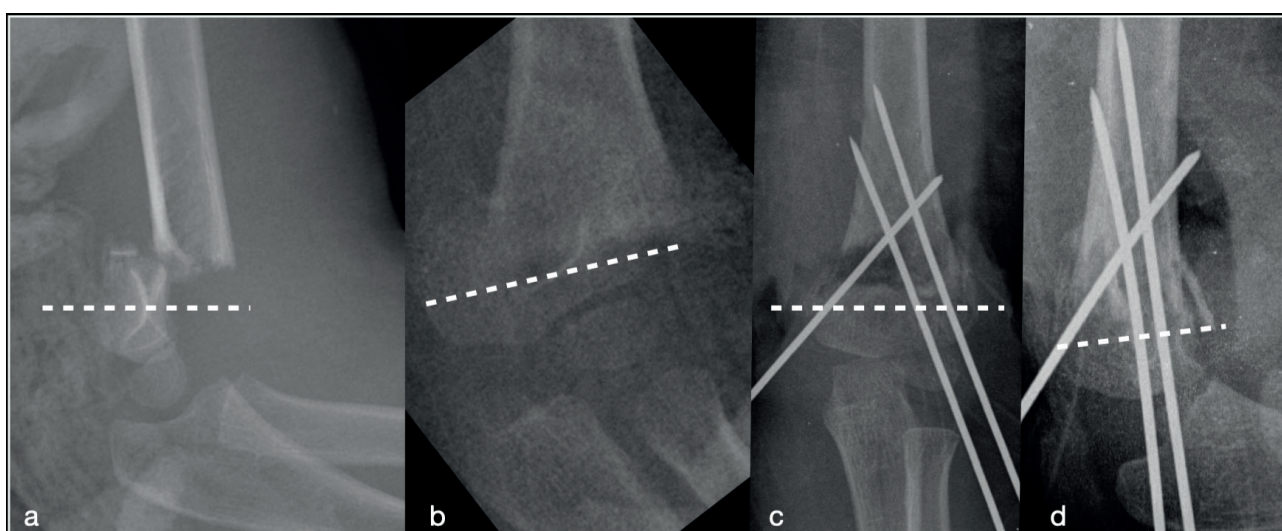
a) Anteroposterior (AP) and b) lateral elbow radiographs demonstrating 5 years old boy with high fracture. c) AP and d) lateral radiograph after K wire fixation.
